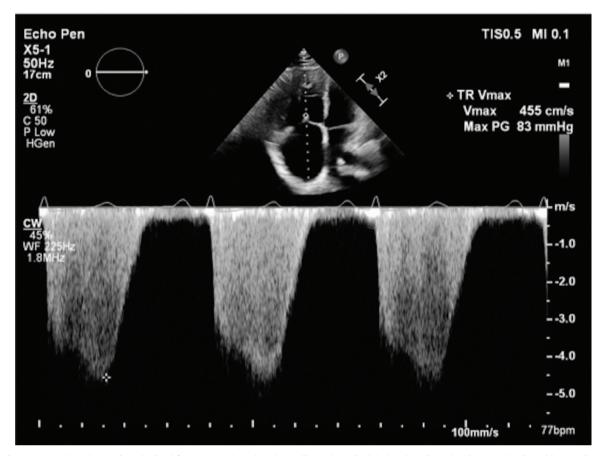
Continuous-wave Doppler tracing obtained from a transthoracic echocardiography apical 4-chamber view showing a peak tricuspid regurgitation pressure gradient of 83 mmHg. The right atrial pressure was estimated to be 15 mmHg, which suggested that the estimated right ventricular systolic pressure was 98 mmHg.
